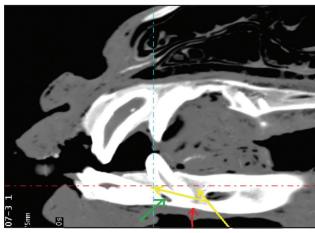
Sagittal plane of CT showing hollowness at either side of alveoli (yellow arrow), opening of anterior mental foramen (green arrow) and less osteogenic thickness (red arrow).
